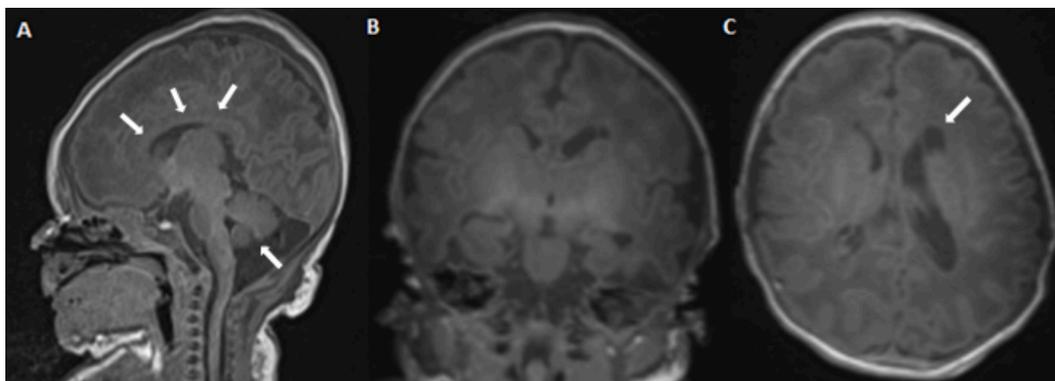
Brain MRI (3 T) Findings at 6 DOL. Sagittal T1-weighted image (A) shows a diffusely thin corpus callosum and inferior vermian hypoplasia (arrows). Coronal (B) and axial (C) T1-weighted images demonstrate multiple subependymal cysts adjacent to the left frontal horn (arrows). Enlargement of the left lateral ventricle is also evident.
